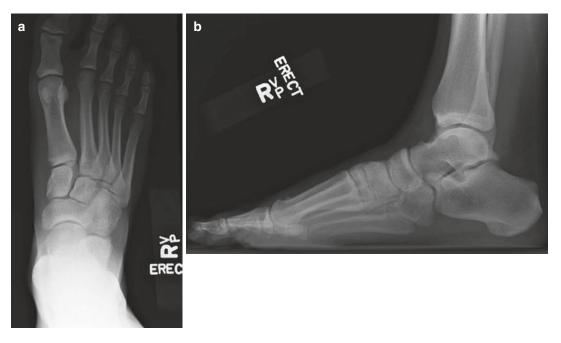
(a) AP and (b) lateral weight-bearing radiographs of an athlete who suffered an on-field right foot injury. No apparent injury is identified on initial imaging
